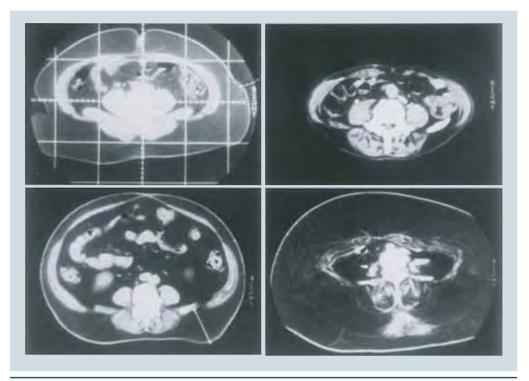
Marked variation of fat distribution in obese subjects. A novel technique for the determination of body fat by computed tomography. Adapted from [8].
